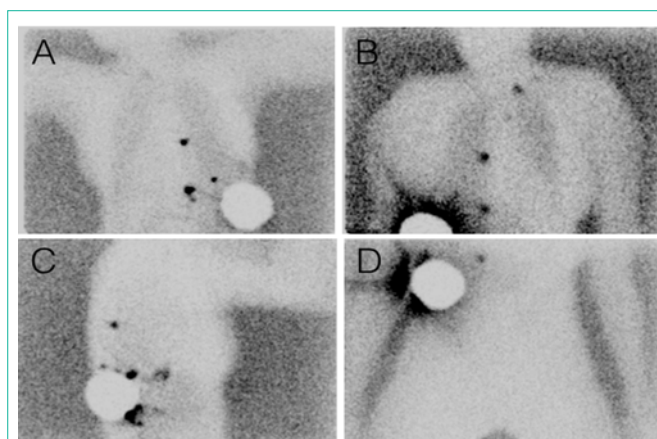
Presurgical lymphoscintigraphy. Posterior view showing three different hot spots in paracostal and paravertebral area (A). Anterior view with several hot-spots in a distribution similar to Figure 1B (B). Right lateral view (C). Anterior view of abdominal/inguinal area showing no uptake in groin basins (D).
